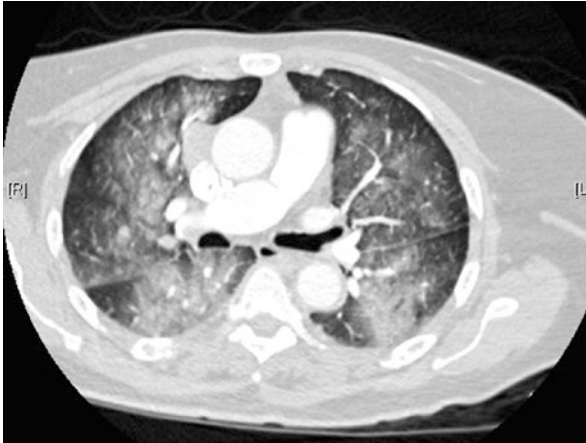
Pneumonitis in a patient with metastatic melanoma. This is a patient who received two cycles of an anti-PD-1 antibody and subsequently presented with hypoxia, dyspnea, and cough. CT scan demonstrated new diffuse bilateral ground-glass opacities, concerning for drug-induced pneumonitis
